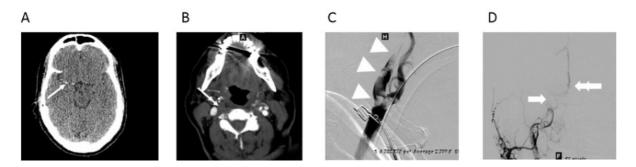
(A) Cranial CT showed dense middle cerebral artery consistent with thrombus (white arrow). (B) CT angiography disclosed occluded right internal carotid artery (double arrow). (C) Digital subtraction angiography confirmed multiple thrombi in the right cervical part of internal carotid artery (arrowheads). (D) Occlusion of the distal internal carotid artery and the middle cerebral artery (large white arrow) with thrombotic material in the anterior cerebral artery (big white double arrow) was seen intracranially.
